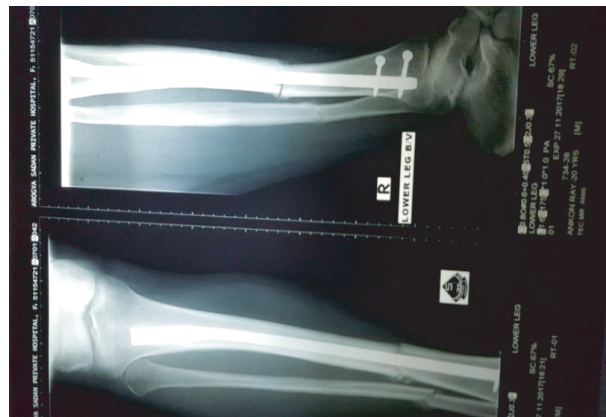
Radiograph at 4 week
